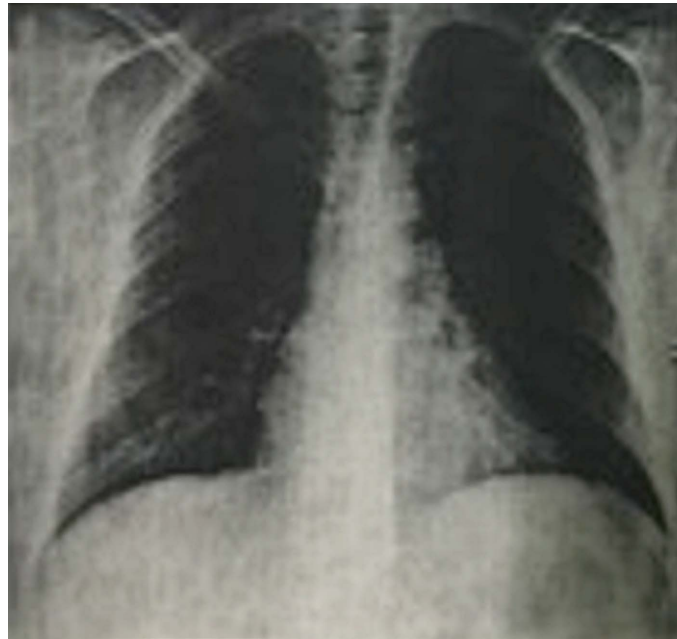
Chest radiography showed an increase in cardiac silhouette.
